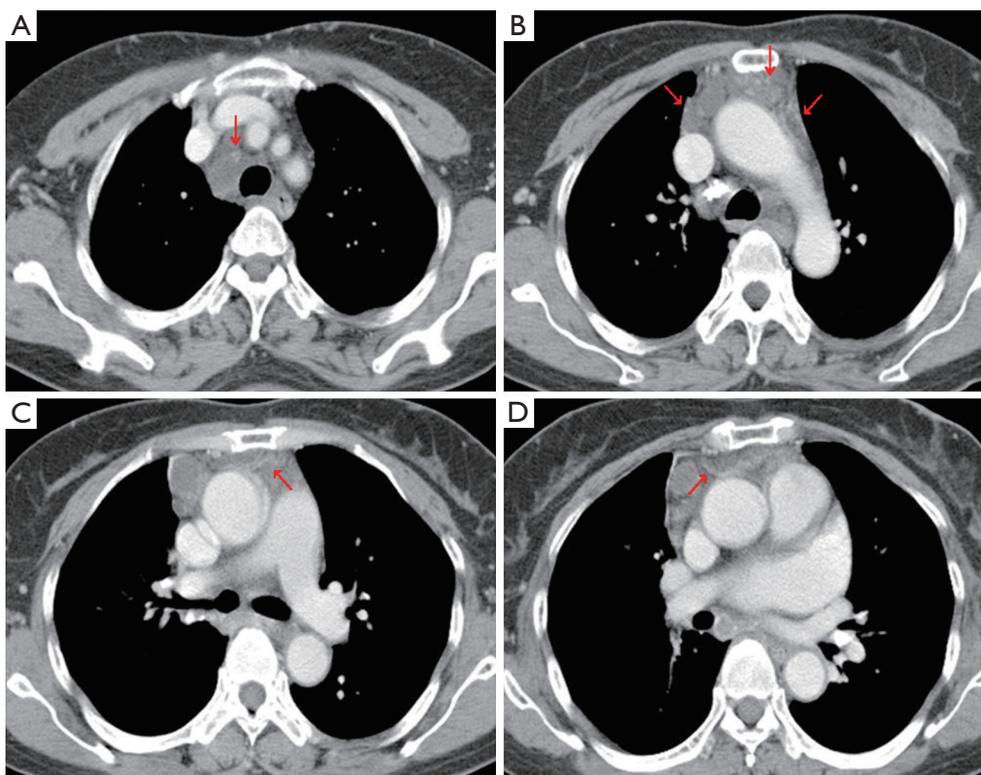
Contrast-enhanced chest CT scan shows multiple conglomerated, nonhomogeneous, low-density masses of 1.8 to 3.0 cm in diameter in the right upper-paratracheal area (A) and anterior mediastinum (B-D). Somewhat streaky, serpiginous, and heterogeneous peripheral enhancements are seen through the small supplying vessels (arrows). CT, computed tomography.
